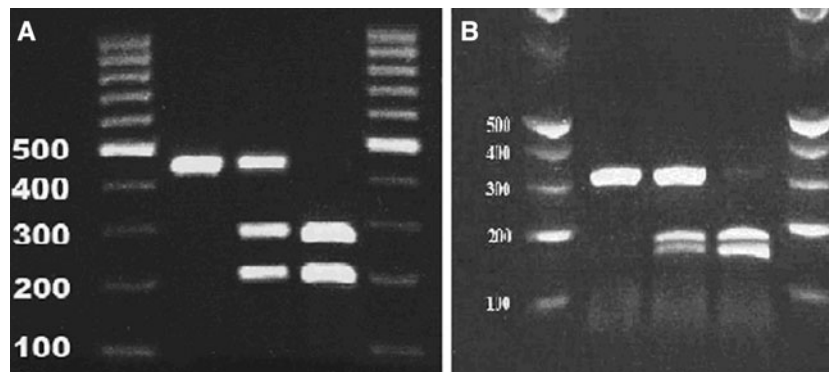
a Genotyping of the TLR9 gene polymorphism by BspTI RFLP: lanes 1 and 5 100-bp DNA marker (Fermentas, USA), lane 2 CC are undigested (423 bp), lane 3 CT are digested into three fragments (172, 251, and 423 bp), lane 4 TT are digested into two fragments (172 and 251 bp). b Genotyping of the TLR10 gene
